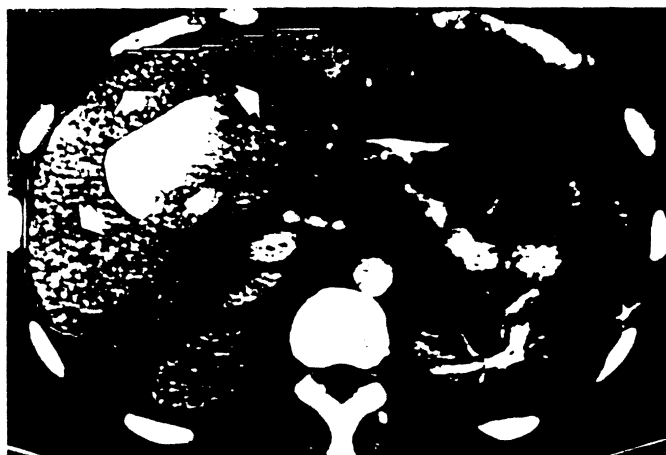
Baboon-to-human liver transplant. Case 1. CT scan of the abdomen performed on postoperative day 24. The CT-calculated liver volume was 1.555cc. The white insert shows the original volume of the baboon liver on the day of the transplant (600cc).
